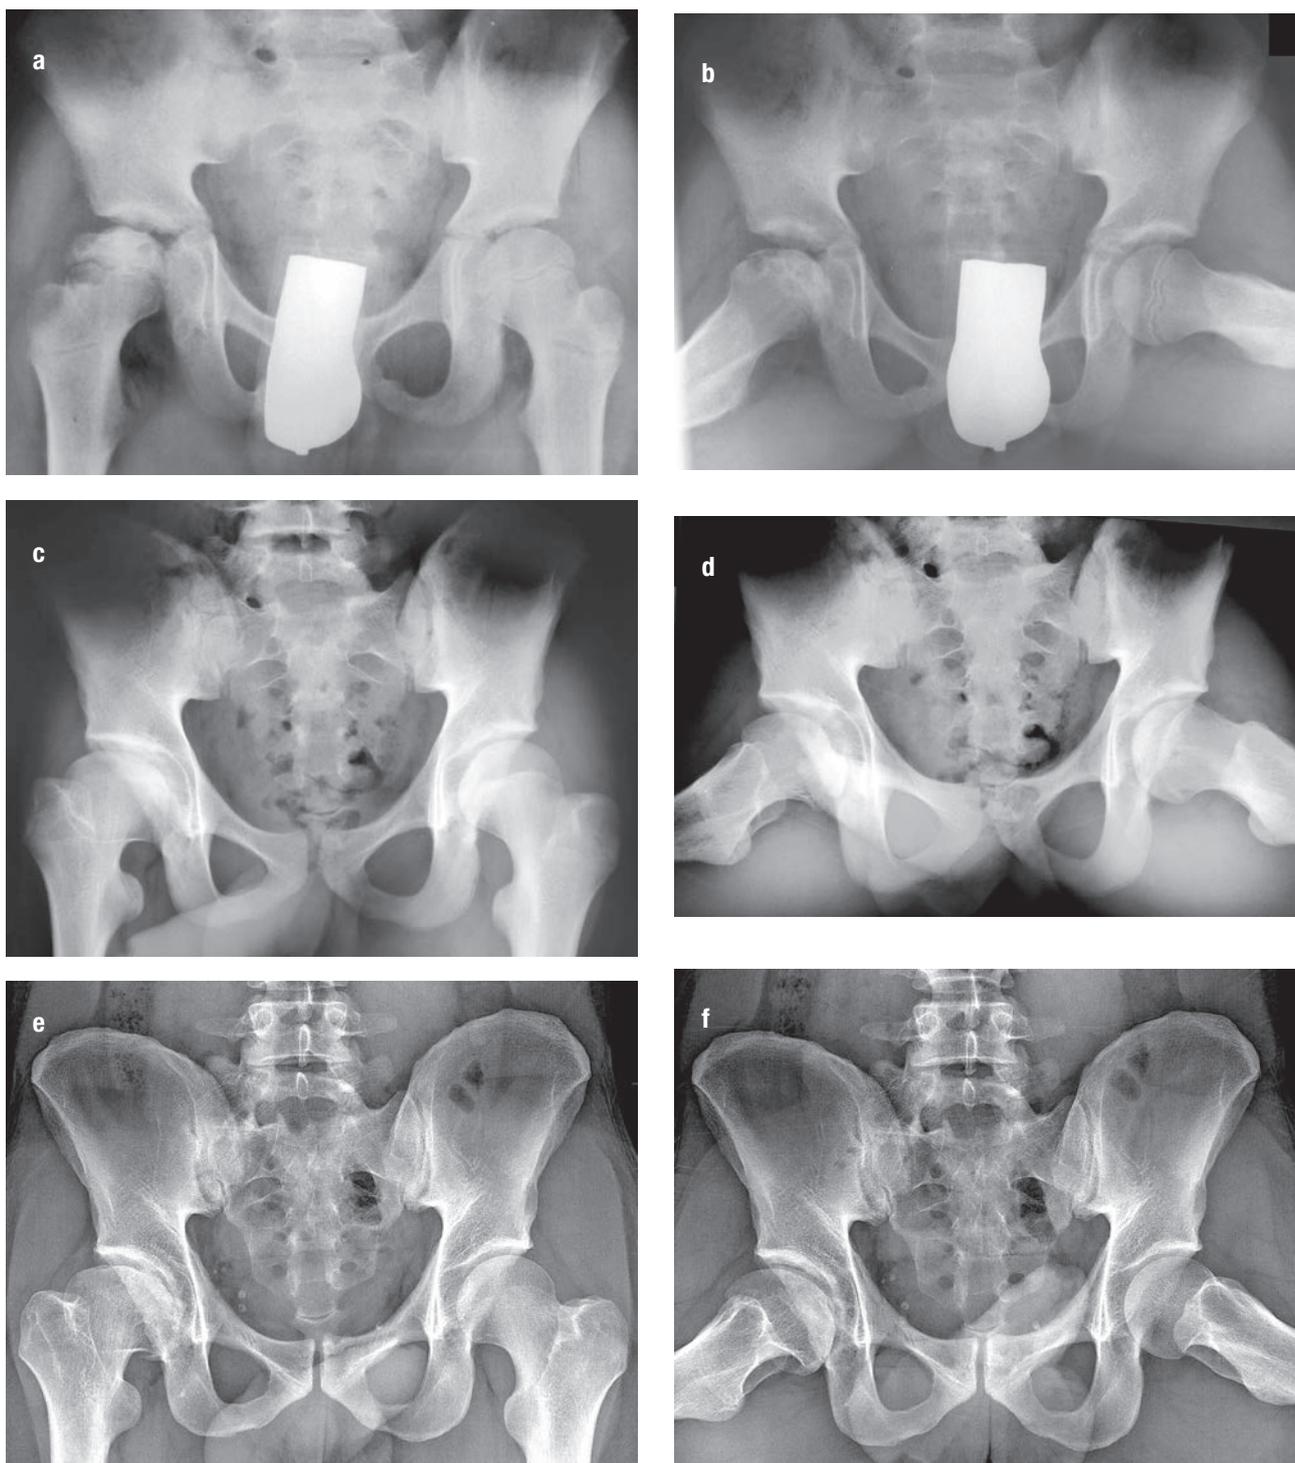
X-ray documentation of twin A, in whom the disease began at the age of 9 years and 9 months: a, b – anteroposterior and Lauenstein views of the pelvis 6 months after completion of “non-containment” therapy; c, d – follow-up images 4 years later; e, f – follow-up images 20 years after treatment shows the coxa planovara on the right with an uneven articular surface of the femoral head a smaller size of the right hemipelvis, and the right-sided fusion of megatraverse process L5.
